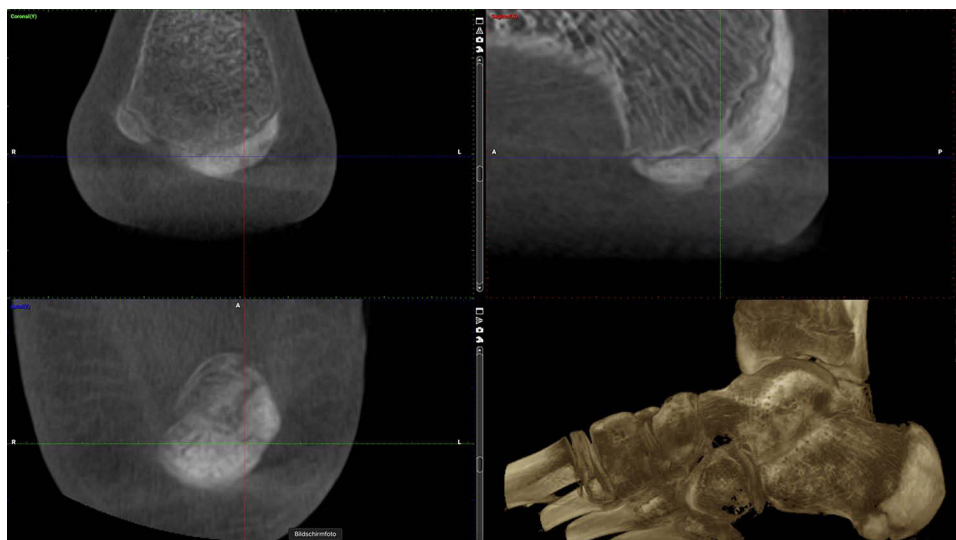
Follow-up weight-bearing CT (WBCT) six weeks after the first combined bone stimulation treatment, which was two weeks after the last session with substantial improvement of the delayed union situation at that early point in time.
